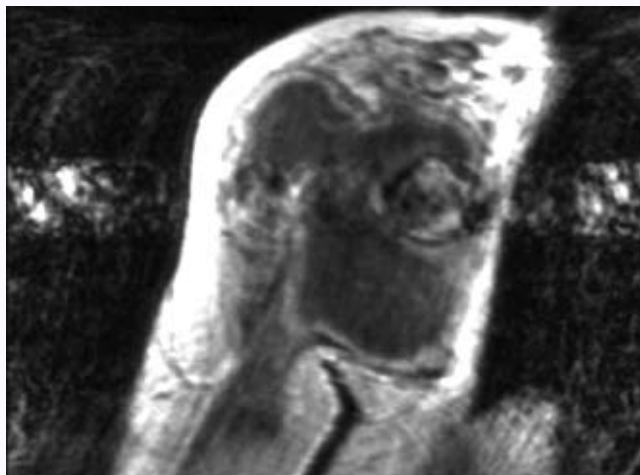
Coronal MRI scan through the right shoulder showing motion artifact.
